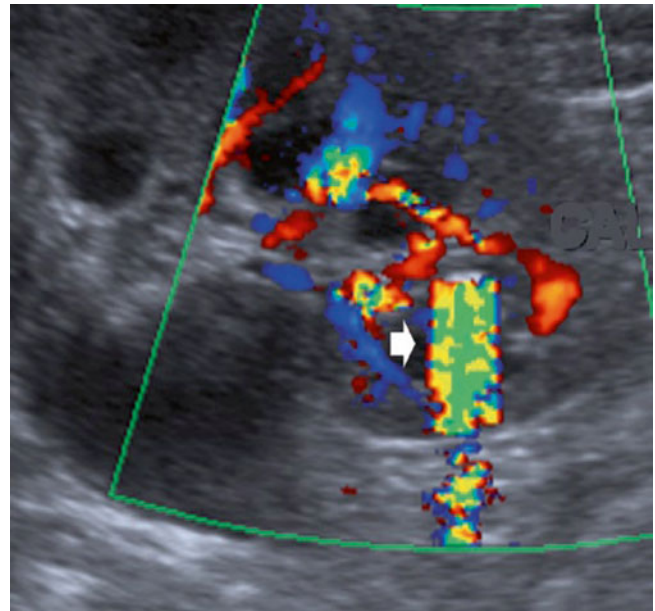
Ultrasound image demonstrating the sparkle sign or twinkle artefact sign (*arrow*) due to a calculus in a lower pole calyx (Courtesy of Dr F Bowyer)
